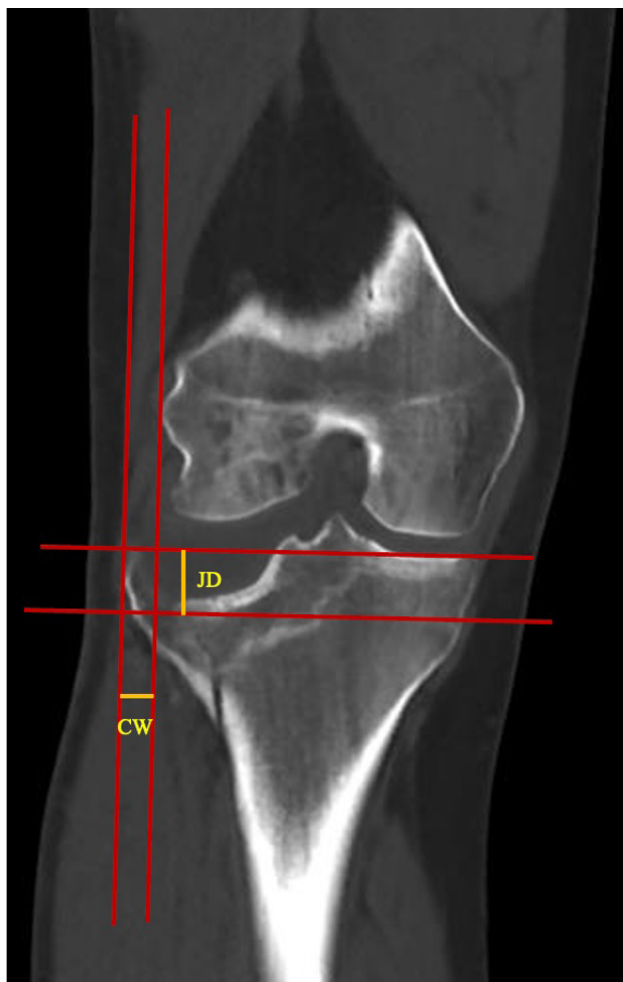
Method of measuring joint depression (JD) and condylar widening (CW) on computed tomography (CT) images. JD is defined as the vertical distance between the tibial joint line and the lowest point of the depressed articular surface. CW is defined as the horizontal distance between the outermost point of the femoral condyle and the outermost point of the tibial plateau.
